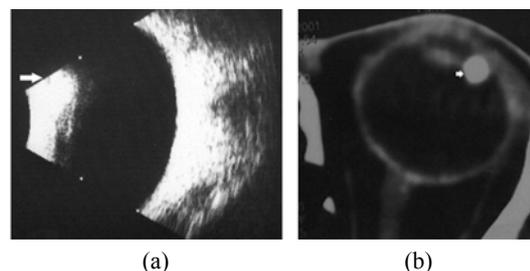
(a) B-ultrasound inspection of left eye revealed a clear-boundary mass in the superotemporal with the size of 4 mm×3 mm; (b) CT examination of the left eye revealed a circular compact mass on ciliary body with the CT value of 251 Hu and the diameter of 4 mm
